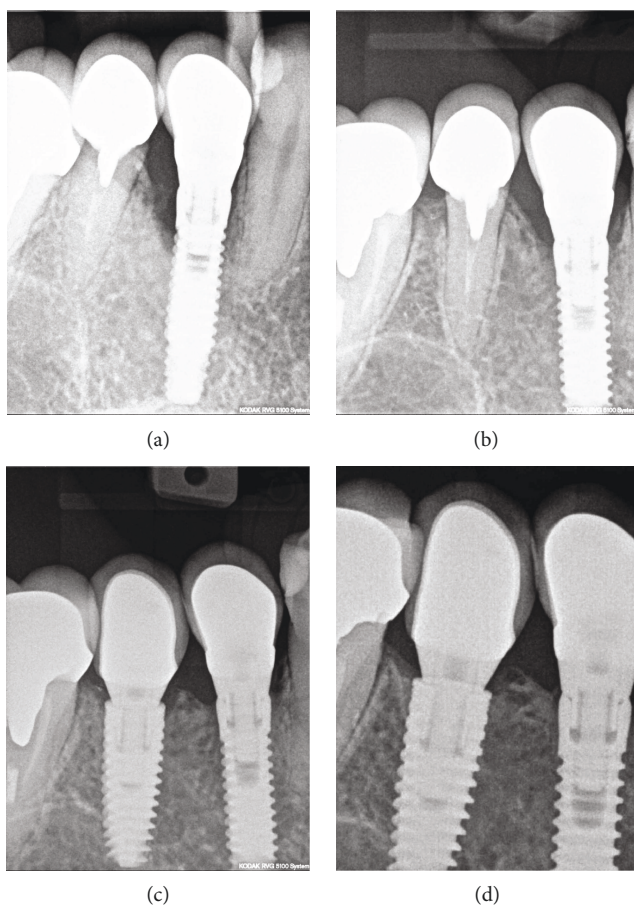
(a) Reference radiograph in 2009; (b) partial remineralization of the bone defect in 2010; (c) full reestablishment of the bone level in 2012; (d) stable bone after 10 years.
